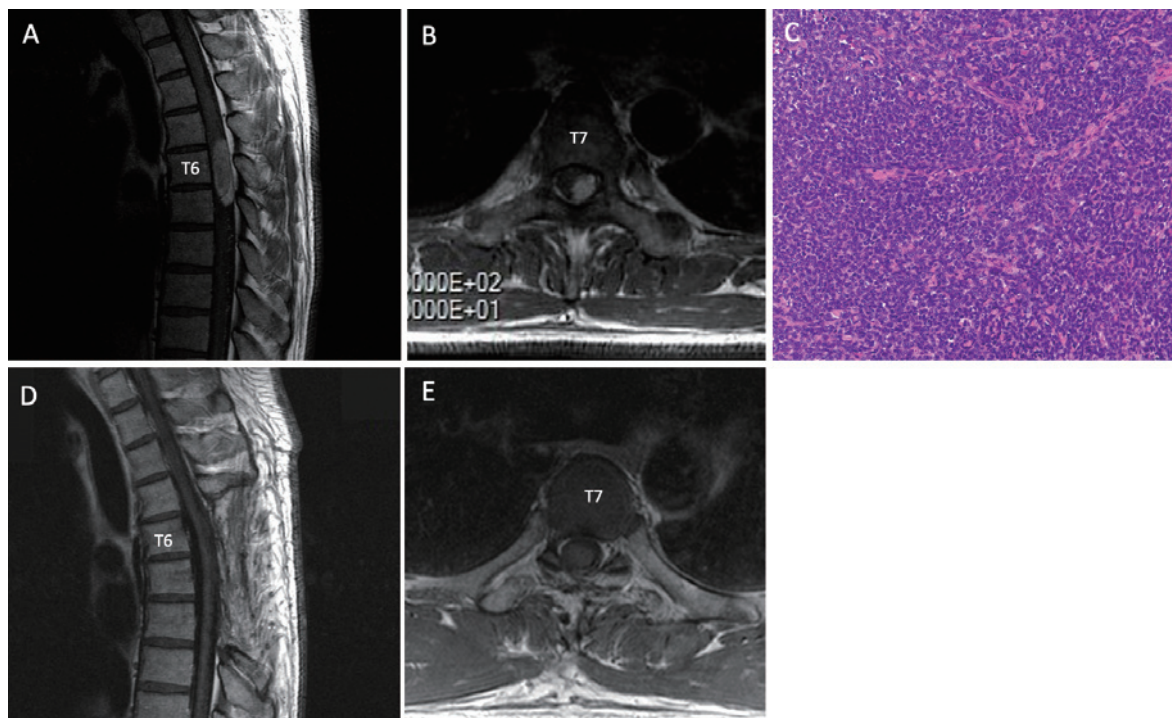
Preoperative and Postoperative follow-up magnetic resonance imaging (MRI) of the first surgery.
